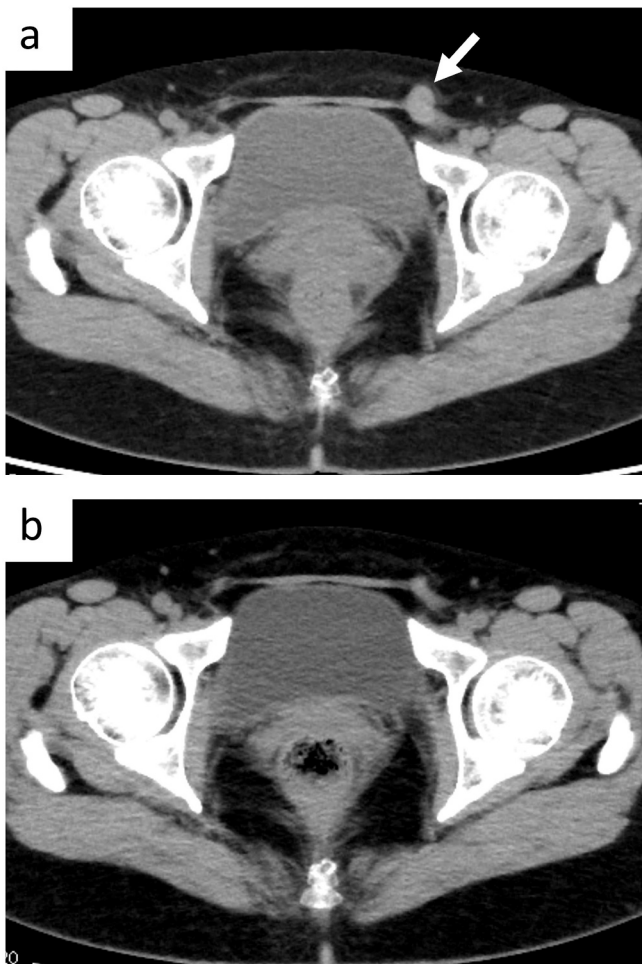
Preoperative computed tomography images. (a) A 20-mm mass in the inguinal region (arrow). (b) The disappearance of the inguinal mass after 2 months of observation.
